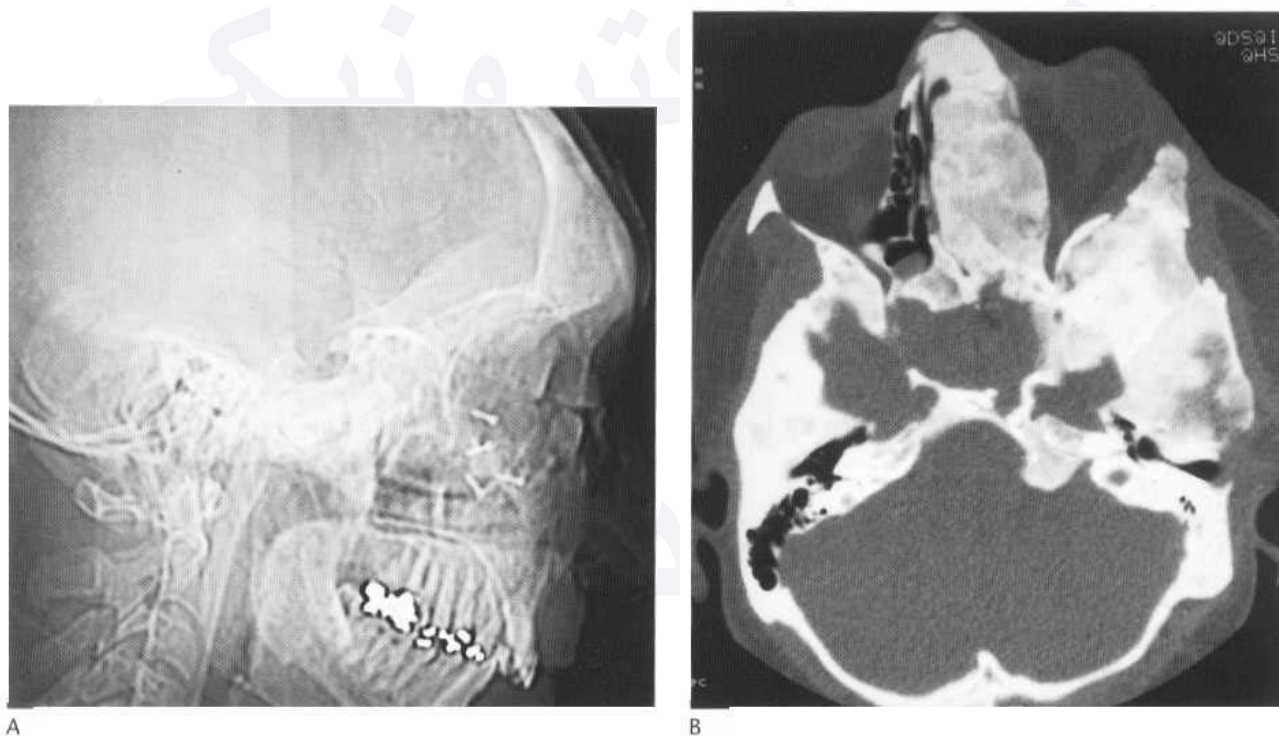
Fibrous dysplasia. (A) There is thickening with sclerosis of the frontal bone, the floor of the anterior cranial fossa and the base of the skull extending back to the sphenoid sinus, which is replaced by dense amorphous bone. (B) The CT scan shows expanded and abnormally mineralised bone occupying mainly the left side of the skull base. Considerable facial deformity is present.
